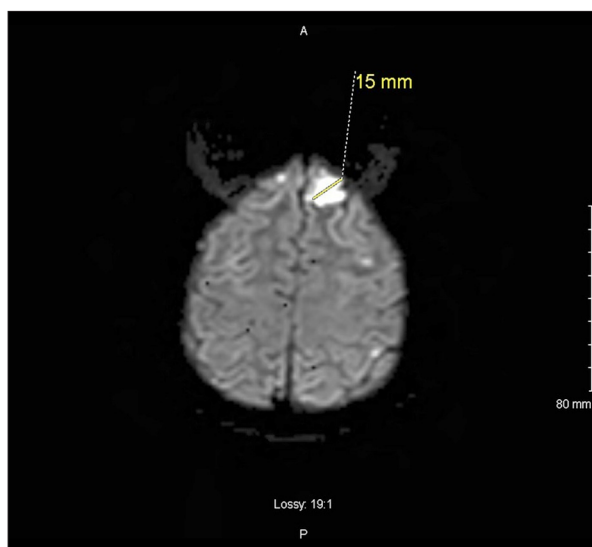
1.5-cm ovoid foci of diffusion restriction with increased FLAIR, raising suspicion of cerebritis.
